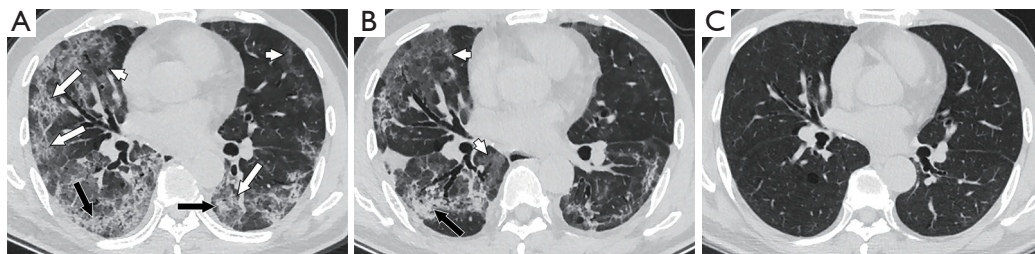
Thin-slice CT scan of a 48-year-old man with COVID-19 with dyspnea after discharge (A-C obtained at 35, 66 and 284 days after onset, respectively). Lesion volume was largest in the peak period, mainly manifested as crazy-paving patterns (white arrows), with some GGOs (white arrowheads) and a small amount of consolidations (black arrows) (A). At discharge, the lesion range was reduced, most of the crazy-paving patterns had disappeared, and the lesions mainly presented as GGOs (white arrowheads) and consolidations (black arrow) (B). In the follow-up CT at 284 days after discharge, almost all the lesions had been absorbed (C). CT, computed tomography; COVID-19, coronavirus disease 2019; GGOs, ground-glass opacities.
